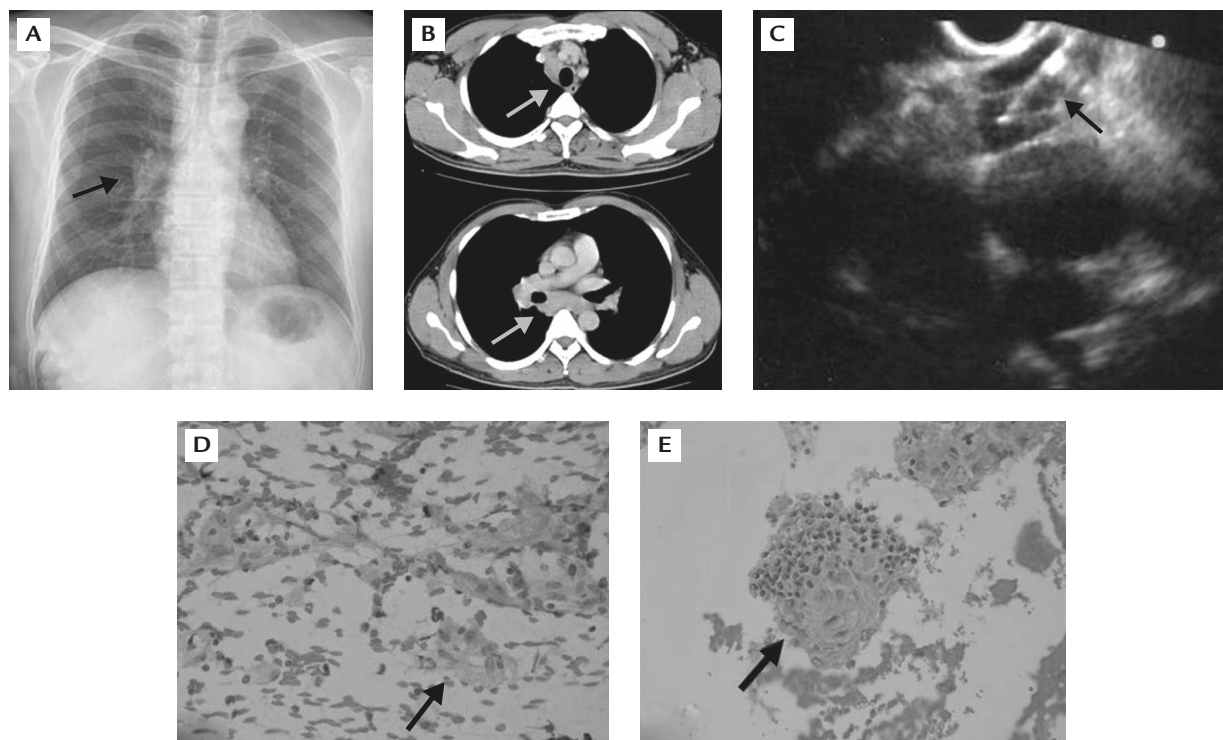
Sarcoidosis diagnosed by EUS-FNA. (A) Chest X-ray shows enlarged hilar lymph node (arrow). (B) Computed tomography shows enlarged mediastinal lymph nodes (arrows). (C) EUS-FNA of mediastinal lymph node, station 7 (arrow). Non-caseating granuloma is shown on: (D) cytology (arrow; 400 \times); (E) EUS-FNA biopsy (arrow; 400 \times).
